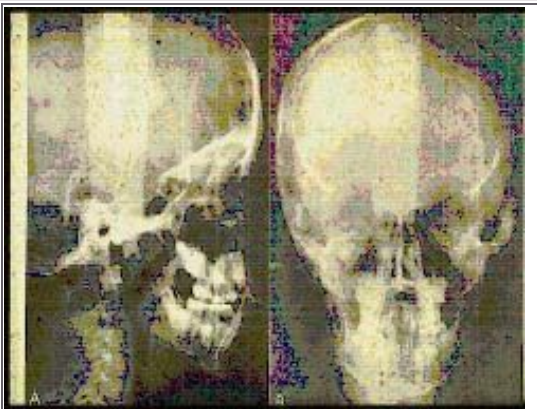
Lateral and frontal cephalometric radiographs
